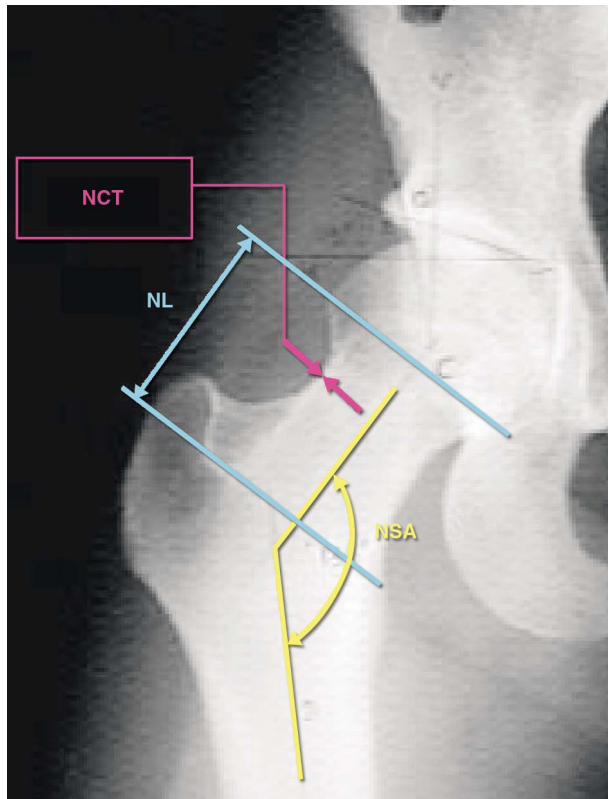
Three geometric variables investigated in the present study as stress fracture risk factors for the femoral neck, as marked on an X-ray image of a human hip joint (NCT = neck cortical thickness, NL = neck length, NSA = neck-shaft angle).
